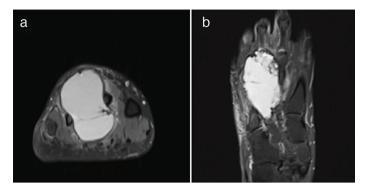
a-b. After 6 months of sclerotherapy treatment, a significant progression in lesion sizes and local recurrence on proton density short and long-axis MRI sequences.
